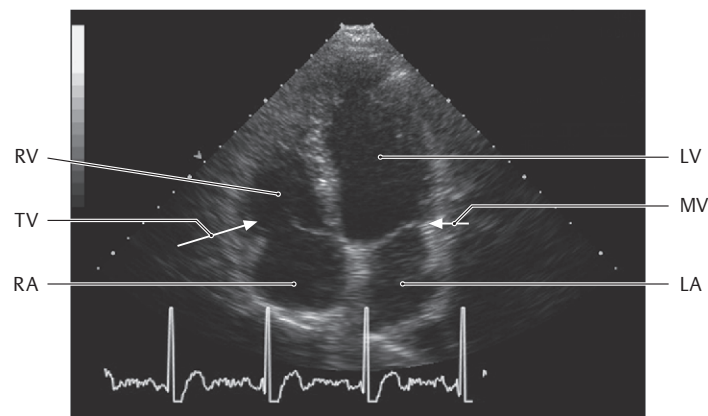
Echocardiogram (heart ultrasound)
